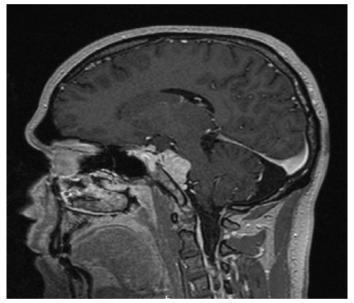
Cranial T1-weighted sagittal MR with contrast.
